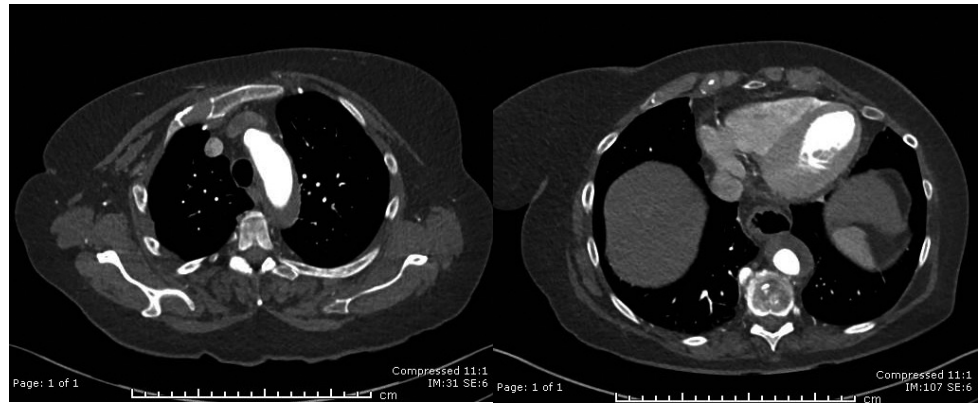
Initial computed tomography angiogram of aorta demonstrating type B aortic dissection.
